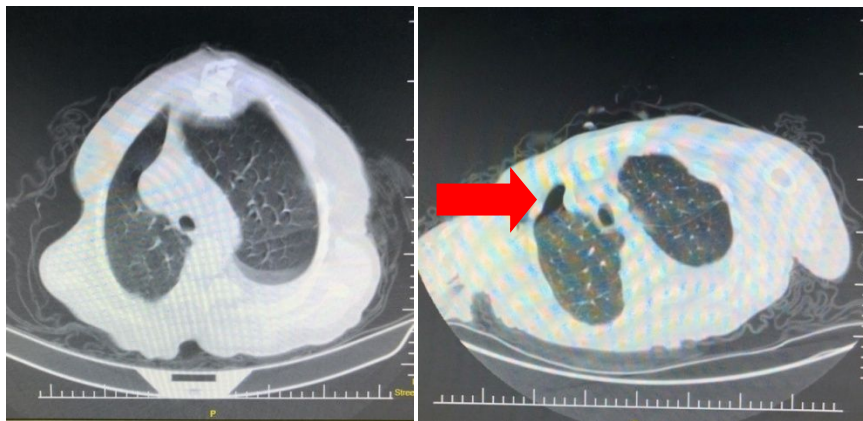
Non-Pnx thoracic CT
